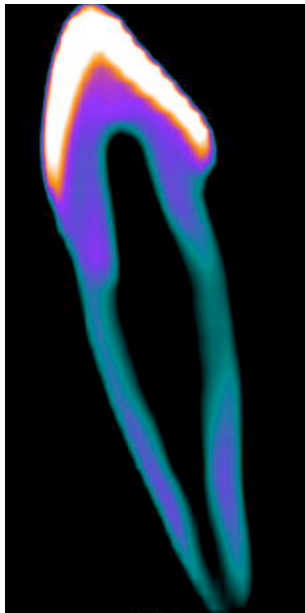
Reconstructed CT image of tooth with tooth volume marked.
